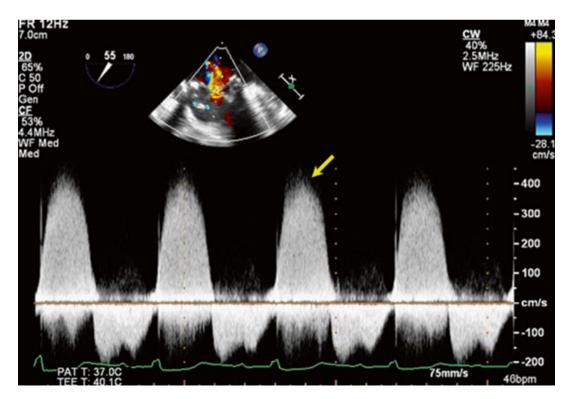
2D TEE continuous-wave Doppler, status post tissue MV replacement, high pressure gradient MR (*arrow*) was present
